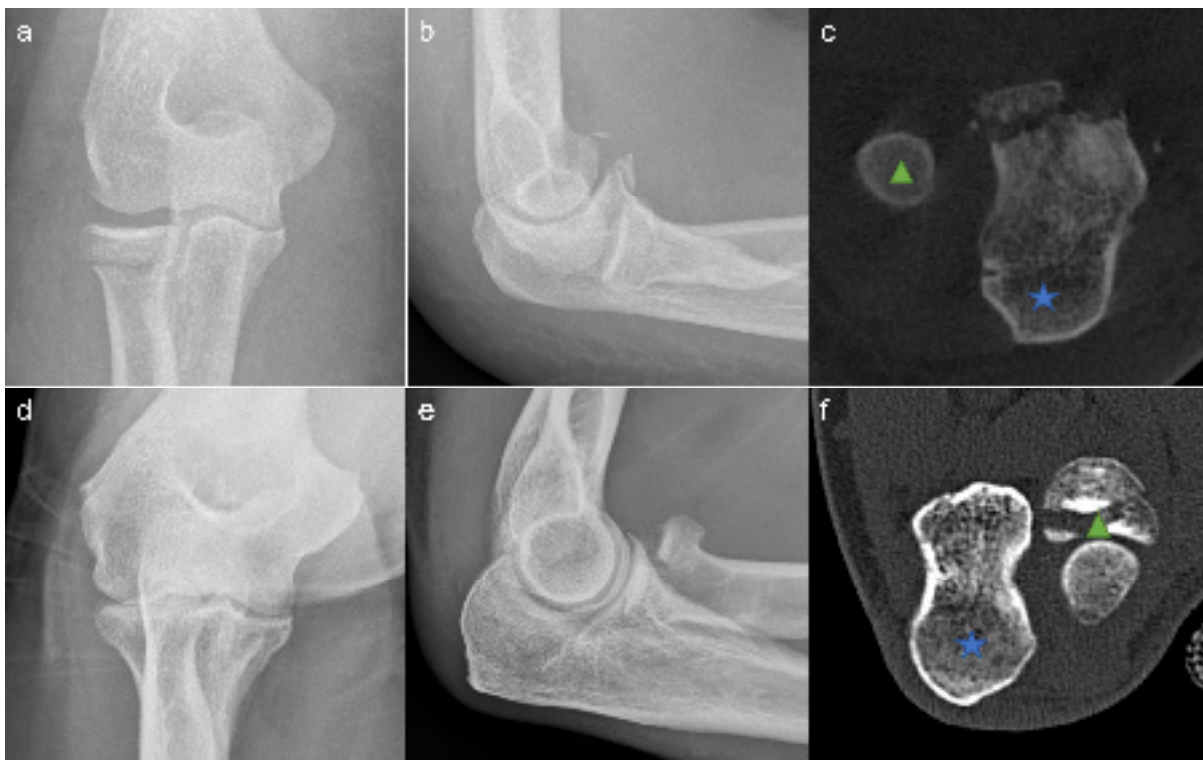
Patient with x-ray imaging of the elbow and presence of a RHF MA Type 1 and a CPF (a-b). Using a CT-scan, CPF can be classified as OD Type 1 (c; green triangle: radial head; blue star: CP). Another patient with x-ray imaging of the elbow presents a RHF MA Type 3 without a CPF, confirmed by a CT-scan (d-f, green triangle: radial head; blue star: CP).
